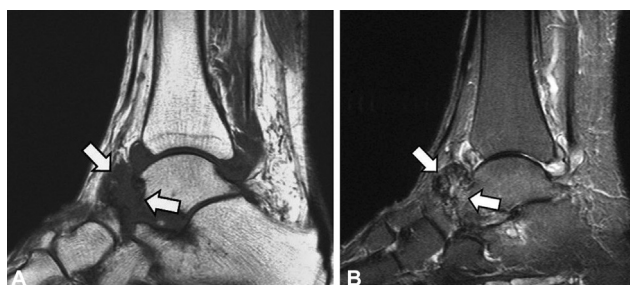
A 51-year-old man with history of rheumatoid arthritis and ankle mass. Sagittal (A) T1-weighted and (B) short-tau inversion recovery (STIR) magnetic resonance (MR) images show a predominantly hypointense mass (*arrows*) in the talonavicular joint eroding into the talar head consistent with a rheumatoid nodule.
